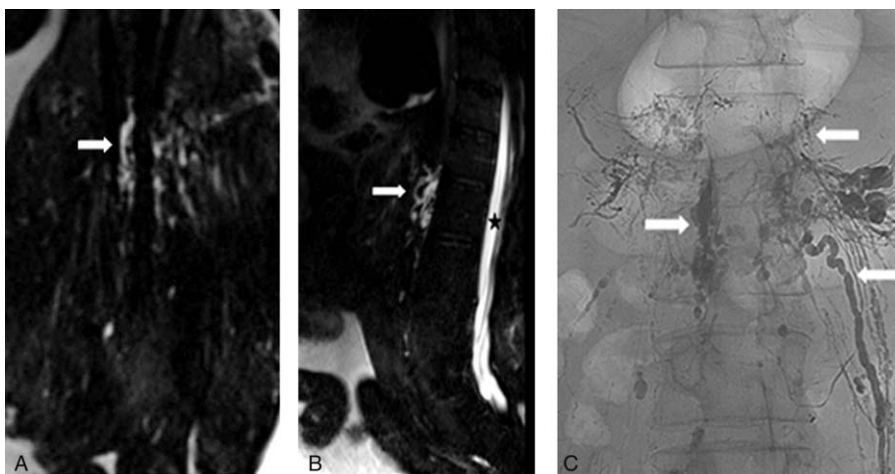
MR and fluoroscopic lymphangiography images of the upper abdomen in a 44-year-old patient with chylous ascites demonstrating abnormal ductal anatomy. Coronal MIP T2 weighted MR image (A) and Sagittal MIP T2-weighted MR image (B) at the level of the upper lumbar spine demonstrate nonvisualization of the cisterna chyli. Instead, there are multiple tortuous central retroperitoneal lymphatic vessels (white arrow). (Spinal fluid = black star). C, Frontal image from direct intranodal lymphangiogram using digital subtraction angiography (DSA) of the same patient at the level of the upper lumbar spine reveals numerous opacified retroperitoneal lymphatic vessels (white arrows).
